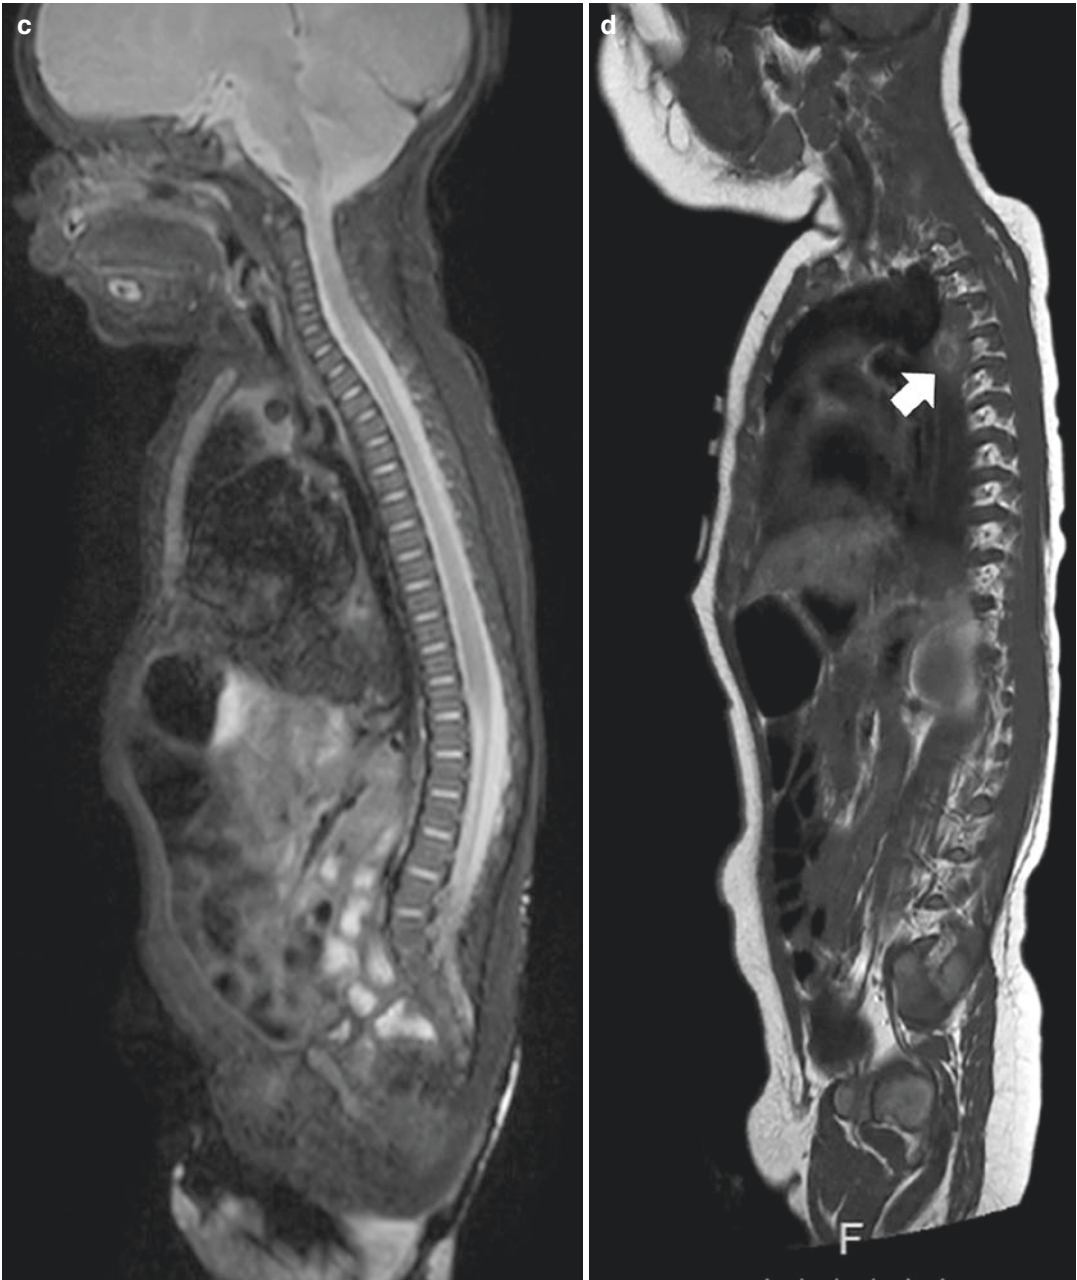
3-month-old boy presenting with inspiratory stridor due to thoracic tumor (a; white arrow) located in the posterior mediastinum with extension in the neuroforamen Th3–Th4 (open arrow). With ultrasound-guided biopsy, a neuroblastoma, standard risk was diagnosed. The bone marrow biopsy appeared normal. At presentation diffuse low T1 signal of the bone marrow is seen, isointense compared to the intervertebral disc (b with zoomed insets; white arrowhead indicating the intervertebral disc) and muscles consistent with red bone marrow. Furthermore, the signal intensity of the bone marrow at
